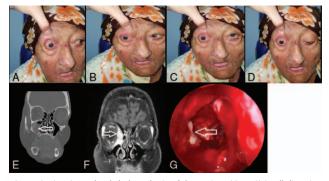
(A-D) Total ophthalmoplegia of the patient (Case 3) in all directions was presented. € White arrow demonstrates the right sided maxillary rhinosinusitis on coronal computerized tomography scan. (F) White arrow show the right sided orbital abscess in contrast enhanced T1 weighted MRI scan. (G) White arrow shows the endoscopic transnasal drainage of the orbital abscess.
